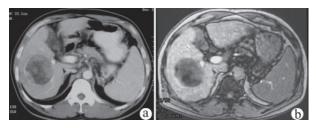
Intratumoral lipid contents in a masslike HCC. (a) Heterogeneous hypo-attenuation area (CT attenuation ranged from 25-38) in the mass on portal venous phase was indicative of intratumoral lipid. (b) Opposed phase imaging demonstrated obvious signal loss in the mass, which was specific for lipid content.
